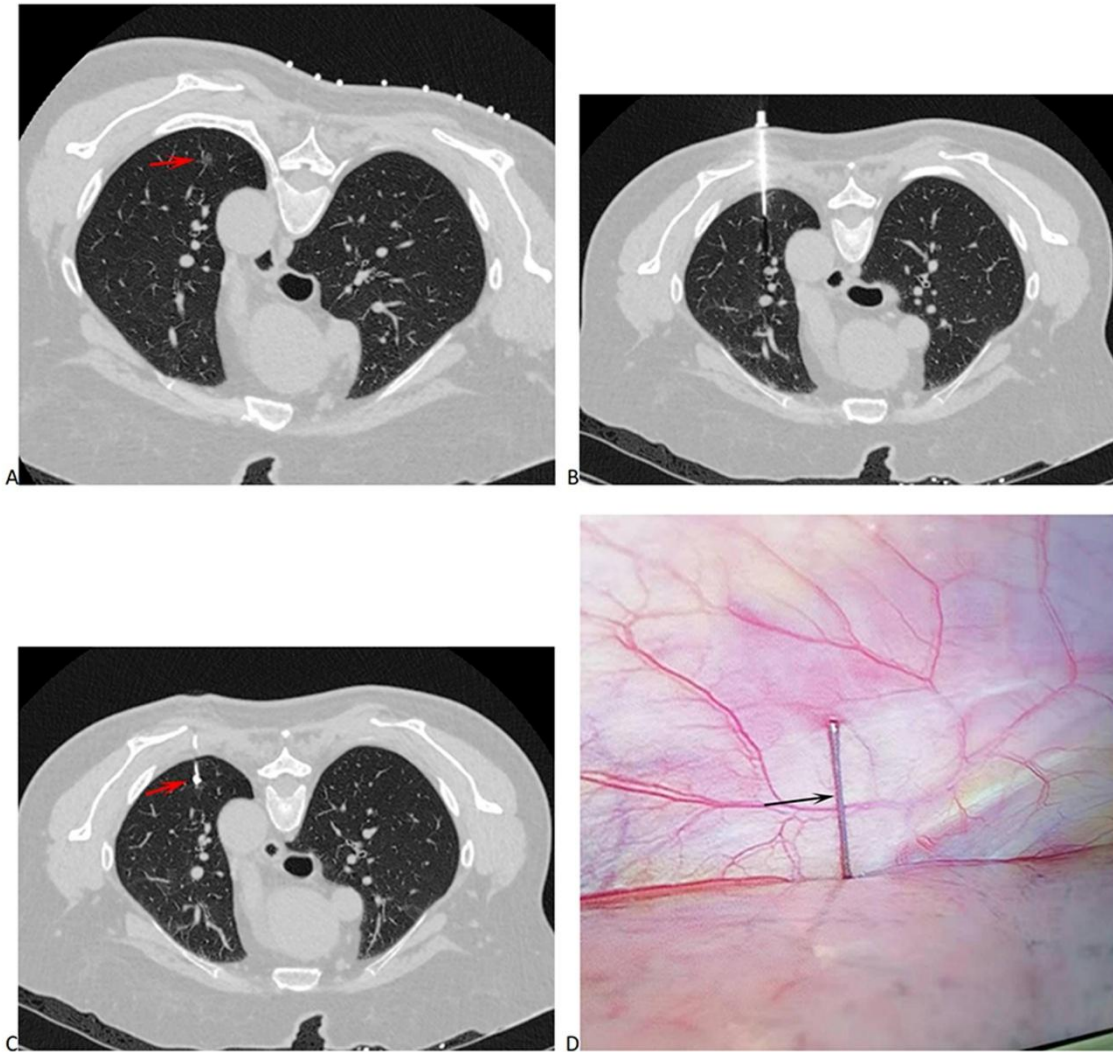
The preoperative computed tomography (CT)-guided tailed coil localization. A – Thoracic CT showed a pure GGN (arrow) at the left upper lobe; B – CT-guided needle puncture; C – Tailed coil (arrow) was placed for PN localization; D – Tailed coil (arrow) could be visualized during the video-assisted thoracic surgery procedure
